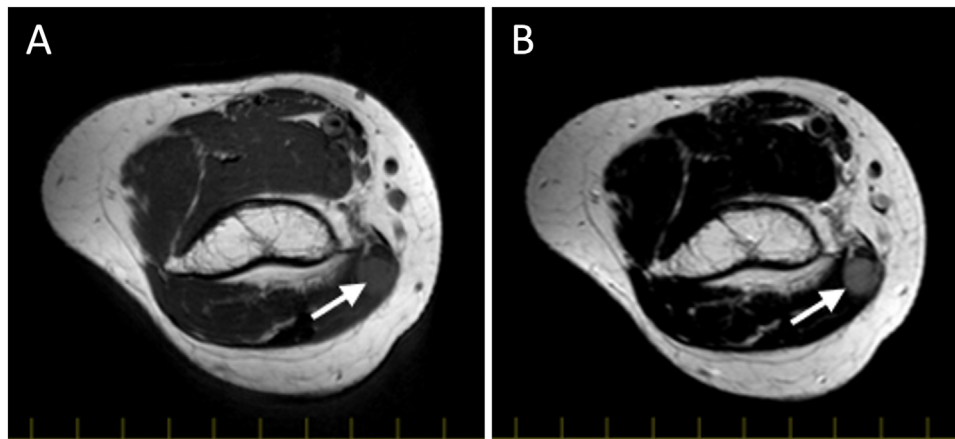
Initial MRI of the right elbow. T1W image (A) demonstrated hypointense signal intensity. T2W image (B) demonstrated hyperintense signal intensity. The lesion was homogenous and attached to the ulnar nerve.
